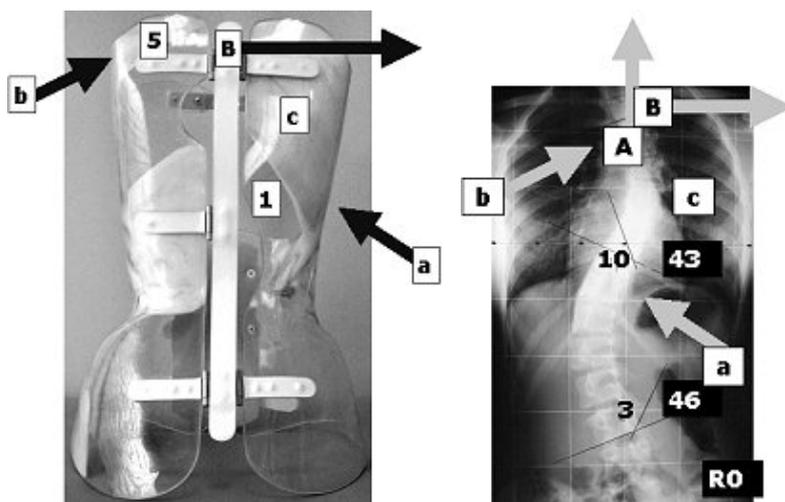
Action of deflection according to SPoRT concept for thoracic scoliosis in the posterior-anterior and radiographic views. Pushes (lower-case letters), escapes (upper-case letters), drivers (numbers) and stops (numbers) are explained in the text. Black letters refer to pushes, drivers and stops on the surface considered, while white letters to controlateral surfaces: e.g. in the lateral view of the brace of next figure the push "a" and the stop "7" are on the right side of the brace (controlateral surface), while all the others are on the left side of it (surface represented).
